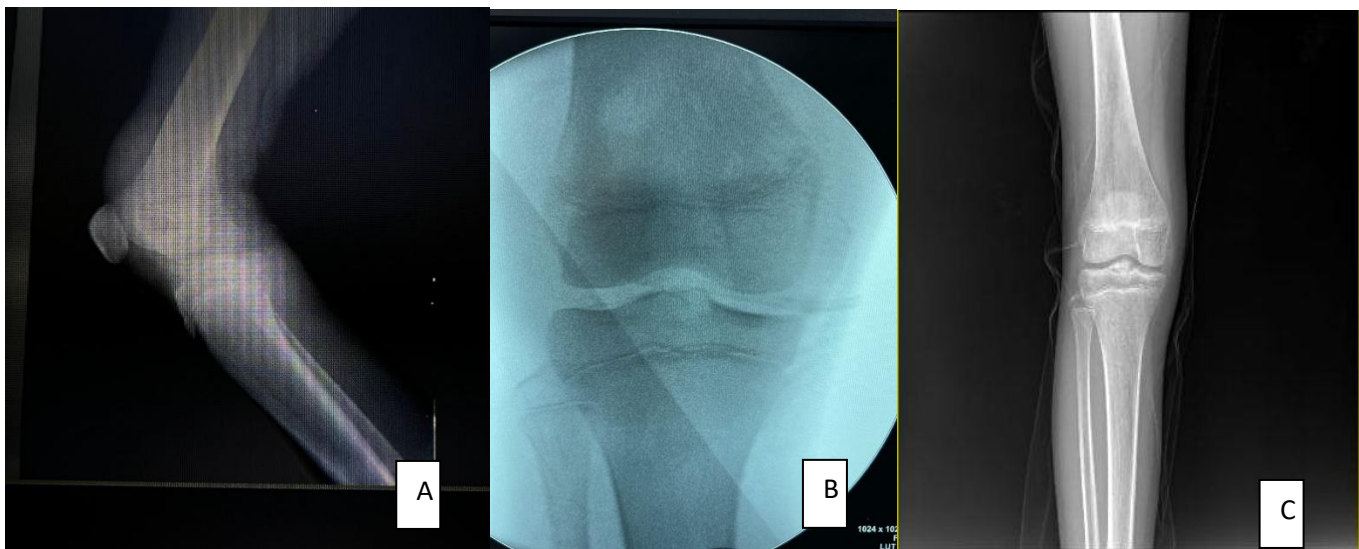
Female patient, 11 years old, presented with avulsed tibial spine fracture type III, fixed by suture technique, (A): Preoperative X-ray, (B): Intraoperative X-ray, (C): Follow-up Postoperative at 6 months A. P view, (D) Follow-up Post operative at 6 months Lateral view
